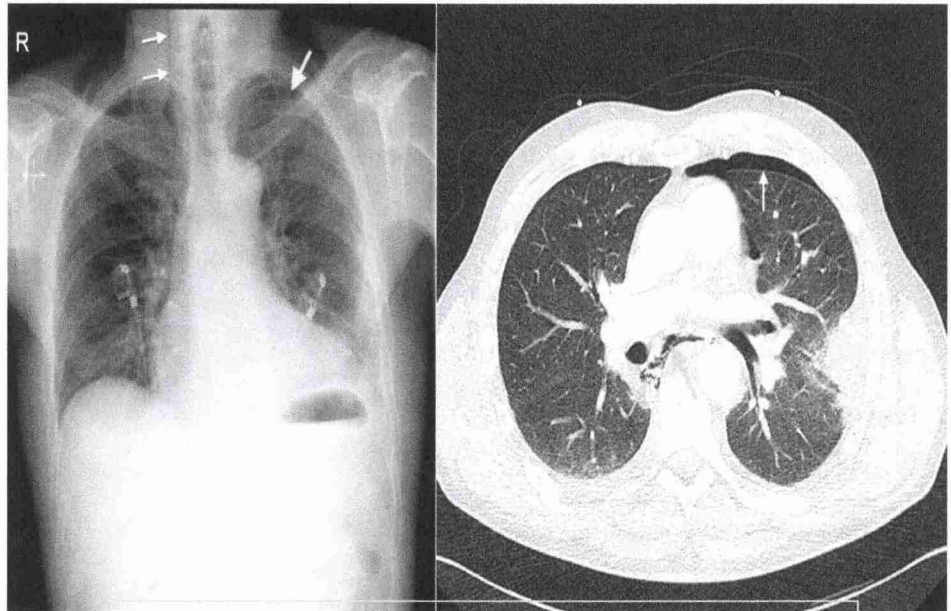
X-ray and CT Thorax showing Oesophageal rupture
